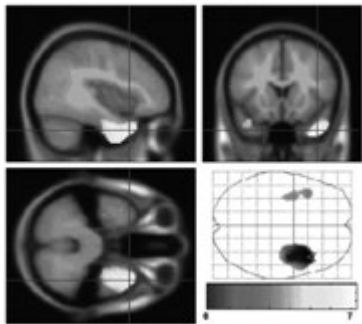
Relative increases of [<sup>18</sup>F]OPN V2 relative to injected volume, in the ipsilateral (right) of the image, unenhanced anterior temporal lobe. Thresholded 1 map overlaid onto T1-weighted average. Maximum intensity projection showing non-specific contralateral increase and absence of charge alterations. Color bar, 1 score.
